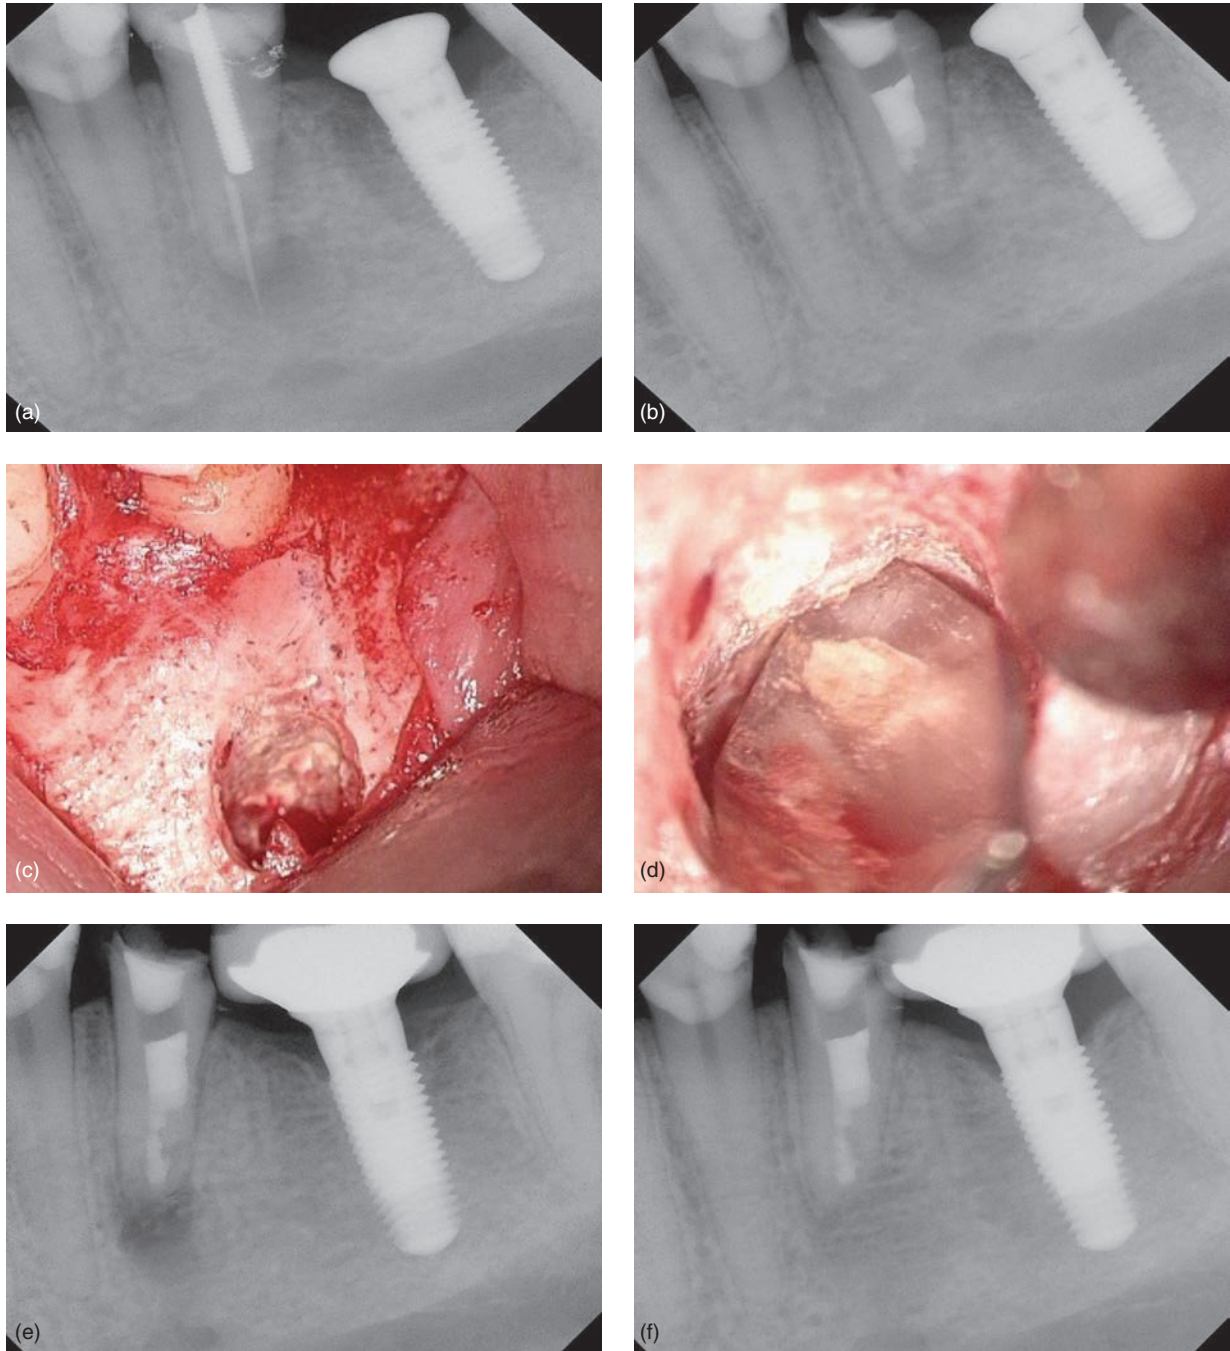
Second left mandibular premolar with insufficient previous root canal treatment, post, resorption, and temporary restoration next to dental implant in area of first mandibular molar. (a) Preoperative radiograph (note mesial bone defect on the unrestored implant fixture); (b) postoperative radiograph after non-surgical retreatment; (c) endodontic microsurgery: surgical treatment helps to avoid difficult implant placement; (d) root end filling in place; (e) postoperative radiograph after endodontic microsurgery (note the vertical step from the distal premolar bone level to the mesial implant bone level); (f) 1 year follow-up; periapical healing on premolar, bone level on implant re-established to first thread.
